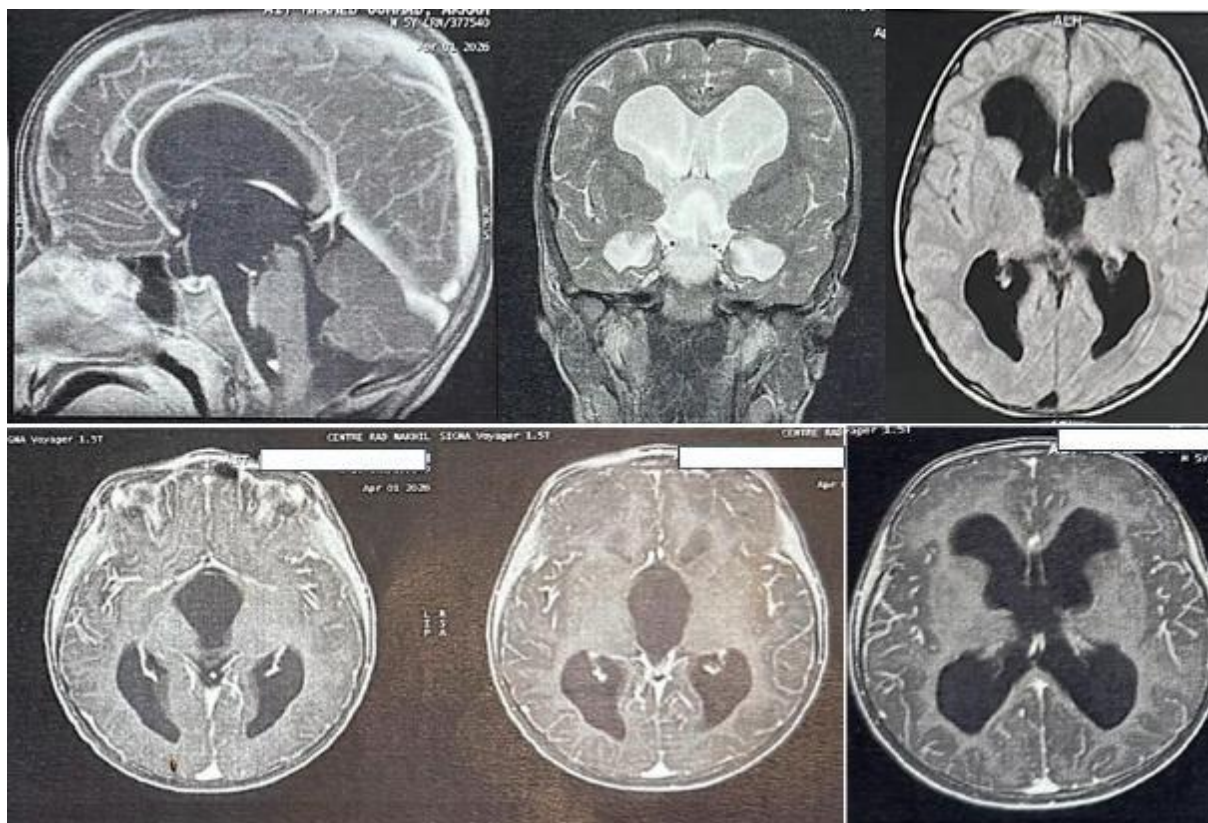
Preoperative brain MRI in axial, sagittal, and coronal planes demonstrating a large third ventricular arachnoid cyst causing marked dilatation of the third ventricle and severe obstructive hydrocephalus
